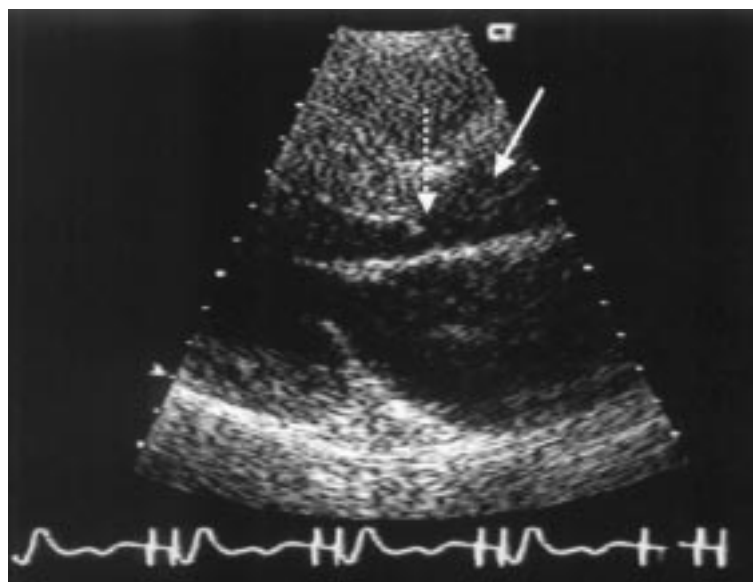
Transthoracic echocardiogram, parasternal long-axis view. Dotted arrow points to LVOT subaortic membrane. Solid arrow identifies the position of the normal aortic valve.
